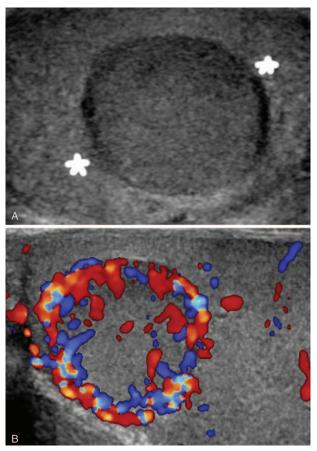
Transverse B-mode ultrasound image (A) showing a $15 \times 13 \times 15$ mm sized well-defined round homogenously hypoechoic mass with a halo at the upper pole of the right testis (white star). Longitudinal color Doppler ultrasound image (B) detecting abundant intranodular and perinodular blood flow signals including veins and arteries.
